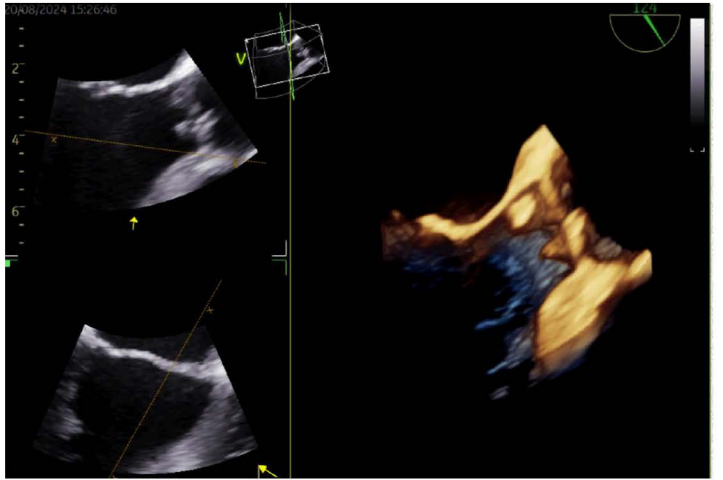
Image of vegetation on the native aortic valve in 3-dimensional transesophageal echocardiography (TEE)
